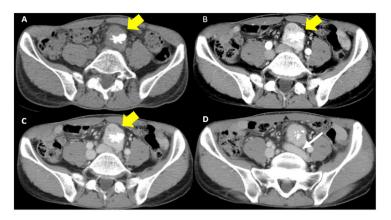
Abdominal and pelvic contrast-enhanced CT findings. (A) CT scan in the non-enhanced phase. The yellow arrow shows the 50x30 mm, well-defined mass with calcification under the bifurcation of the aorta in pelvic retroperitoneal. (B) CT scan in the arterial phase. The imaging revealed an evident contrast enhancement mass. (C and D) CT scan in the venous phase. The white arrow shows the mass is close to left common iliac vein. CT, computed tomography.
